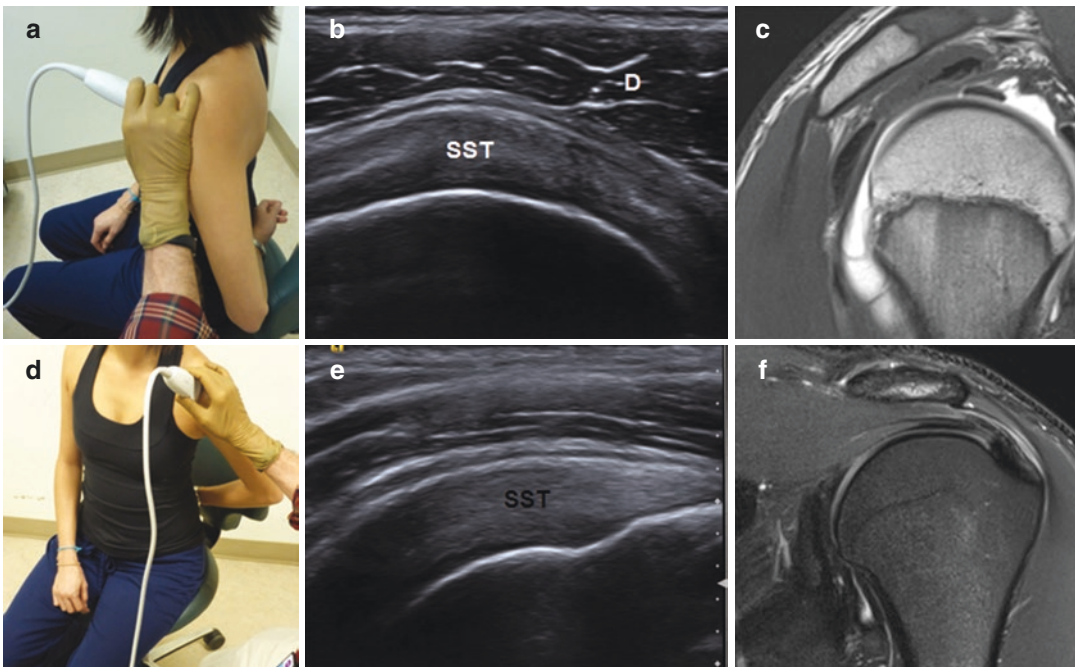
Crass position: supraspinatus/infraspinatus and rotator interval—short-axis patient positioning (a); short-axis sonographic image (b); MR correlate of short
